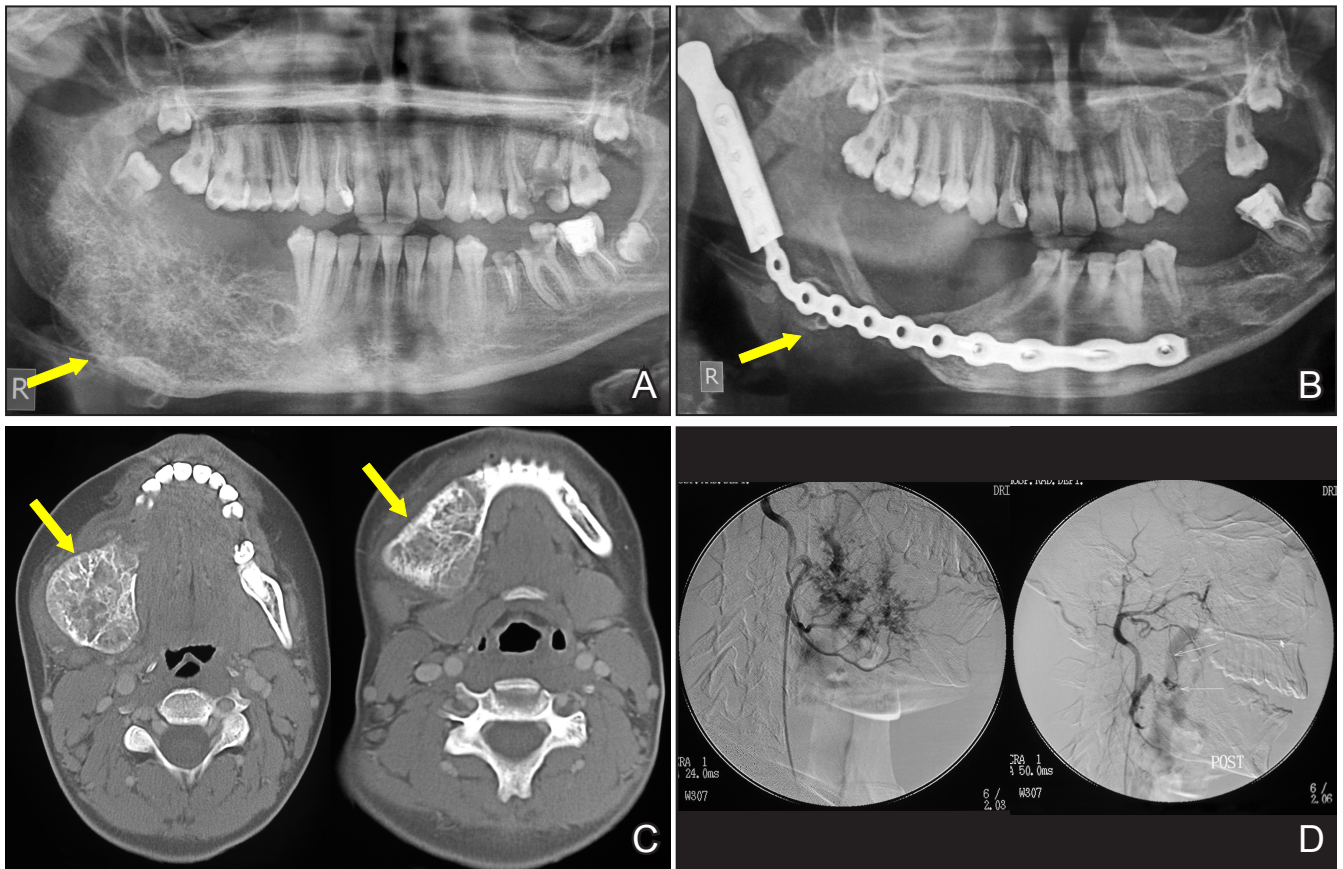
A = initial orthopantomogram of the patient number 3, showing an ill-defined extended IVA at the right side of the mandible; B = orthopantomogram, 20 months after hemimandibulectomy and reconstruction with a 2.5 mm plate (notice the bone growth along the plate); C = initial computed tomography scans of the same patient; D = lateral view with digital subtraction arteriography of the right common carotid artery: left - before embolization, right - after embolization with PVA particles.
